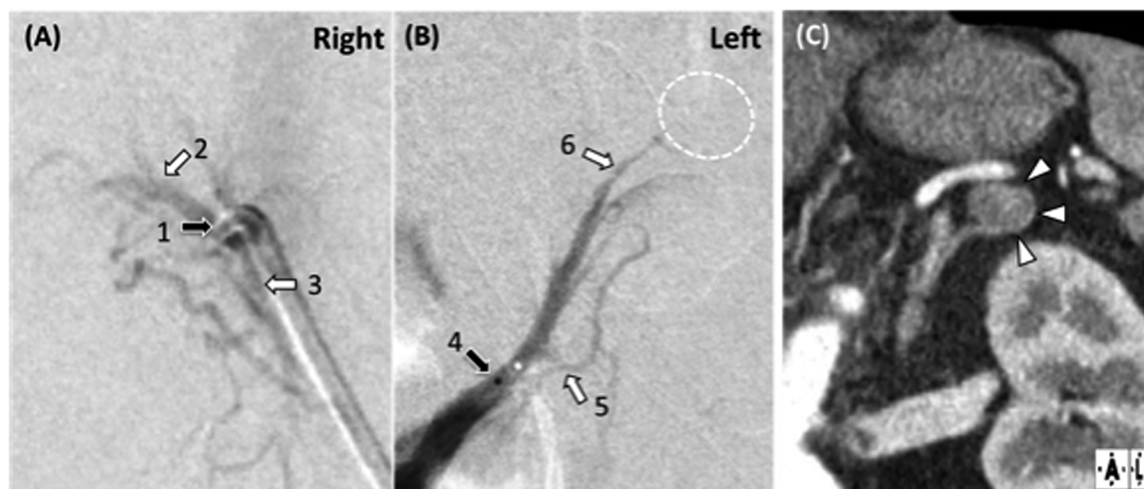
Adrenal venography performed to carry out segmental AVS (A, right side; B, left side) and coronal CT image of the left adrenal gland (C) in a 55-year-old woman who was finally diagnosed unilateral APA. The adrenal tumor was detected by CT (C, arrowheads) and projected into the venography (B, dotted circle). Sampling points from central veins are indicated by black arrows 1 and 4 in (A) and (B), respectively. Sampling points from tributary veins are indicated by white arrows 2 and 3 in (A) and 5 and 6 in (B). Abbreviations: APA, aldosterone-producing adenoma; CT, computed tomography.
